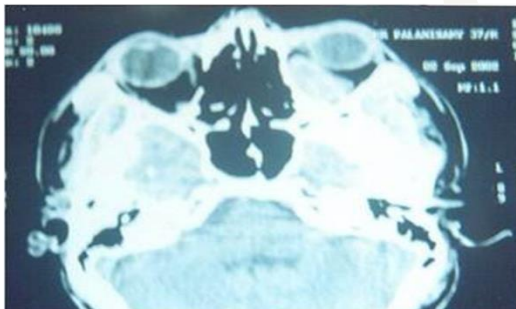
Computer tomography (CT) scan of the orbit showing heterogeneous mass in the apex of the orbit.
